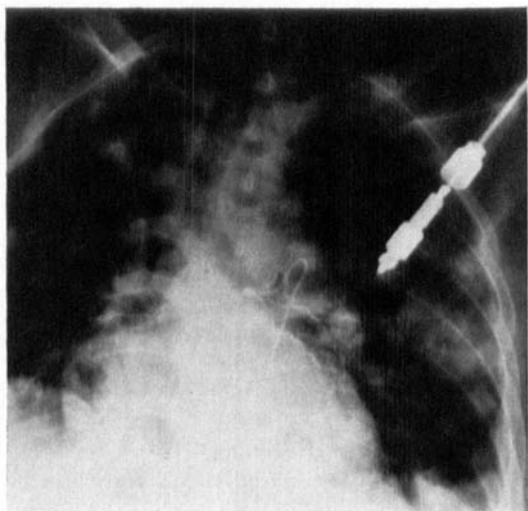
Roentgenogram showing the catheter placed in position for administration of radiosulfate in the bronchial arteries. Vessels visualized by injection of a few ml of contrast solution. Multiple metastases in both lungs. 24 Nov. 1966.
